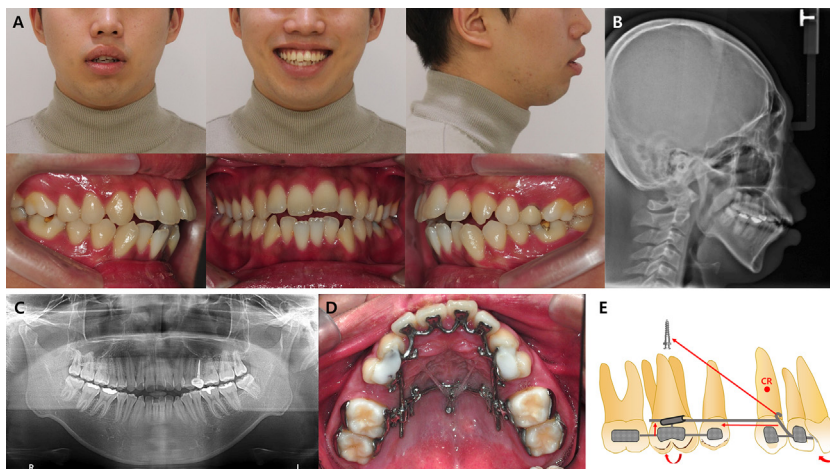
Case 2. Pretreatment data. A: Facial and intraoral photographs, B: Lateral cephalogram, C: Panoramic radiograph, D: Occlusal photo showing the design of the APLR, E: Biomechanics of the APLR.
